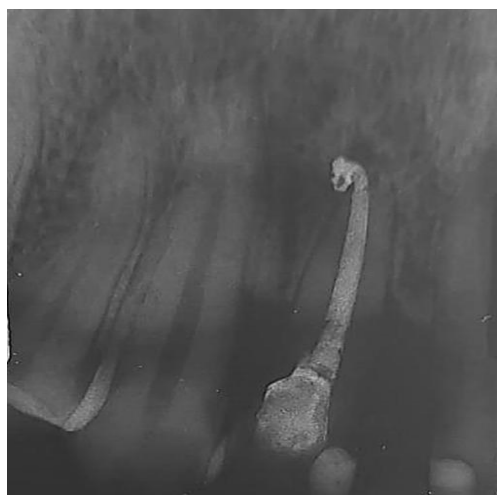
Radiography after 18 months - involution of periapical lesion and loss of radiopaque granules in a perforation region sealed with Portland cement
